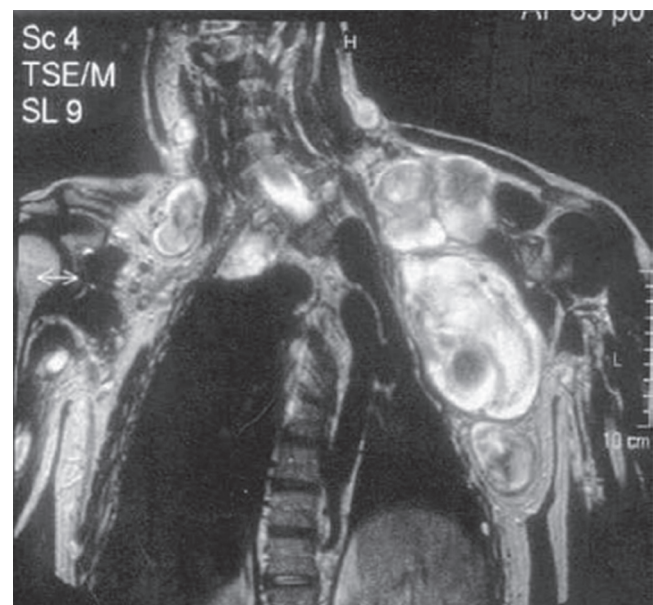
■ MRI showing the coronal plan of T1 image demonstrating lobulated masses in the chest wall. The involvement of the supra- and subclavicular region, severe deformity of the chest, and thoracic scoliosis are clearly evident. (Reprinted with permission from Margaritora S, et al: Giant neurofibroma of the chest wall. *Eur J Cardiothorac Surg* 21:339, 2002.)
